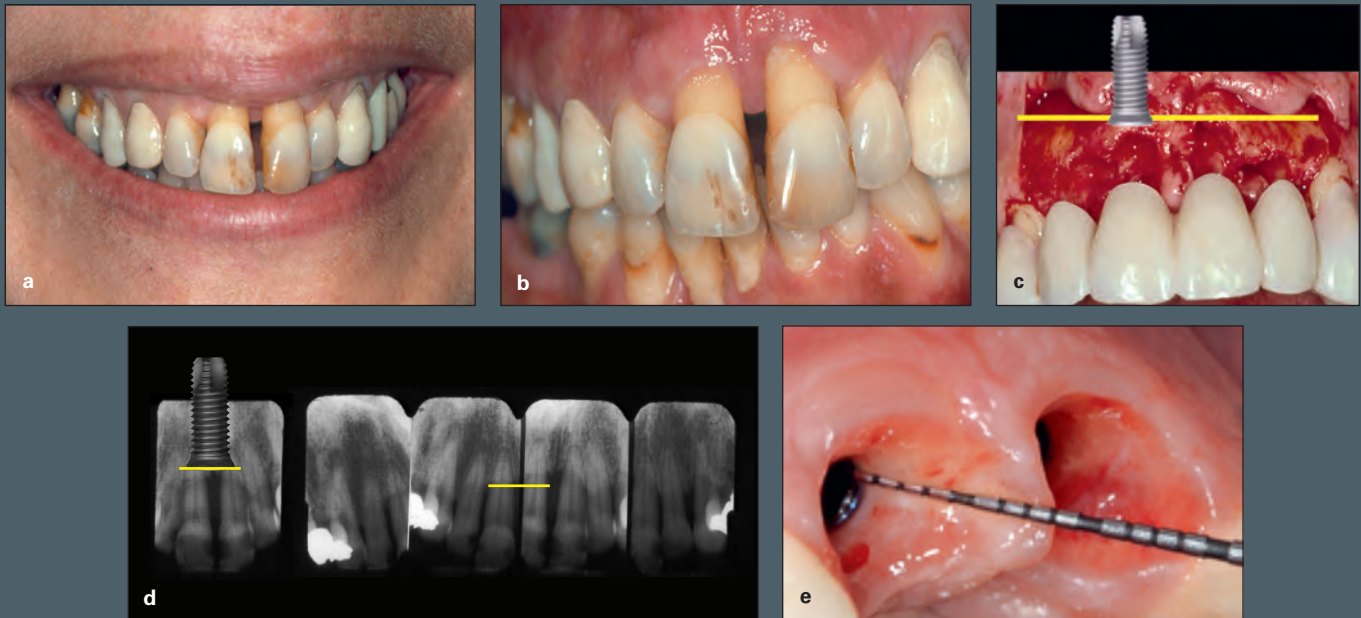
(a) The patient's chief complaint centers on esthetics, but she is unaware of her advanced loss of periodontium. (b) It is evident that there has been a significant loss of supporting bone for these teeth. (c) If implants are placed without significant successful regenerative therapy, the implant-abutment junction will be too apical to allowing cleaning by the patient or the hygienist. The decision was made to remove the teeth and place a provisional partial denture. (d) Radiographs showing the loss of bone. (e) If a patient is susceptible to inflammation, it is important to have structures in a position where the hygienist and patient can decontaminate the components of the restoration, such as the implant abutment and prosthetic restoration.
